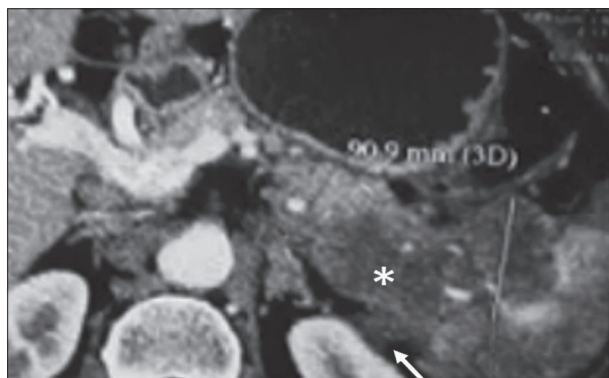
Coronal reformatted computed tomography image in the late arterial phase shows a large tumor (asterisk) with infiltration of the perirenal fat on the left adrenal capsule (arrow); also note infiltration of the hilus of the spleen with consequent infarction of the splenic parenchyma
